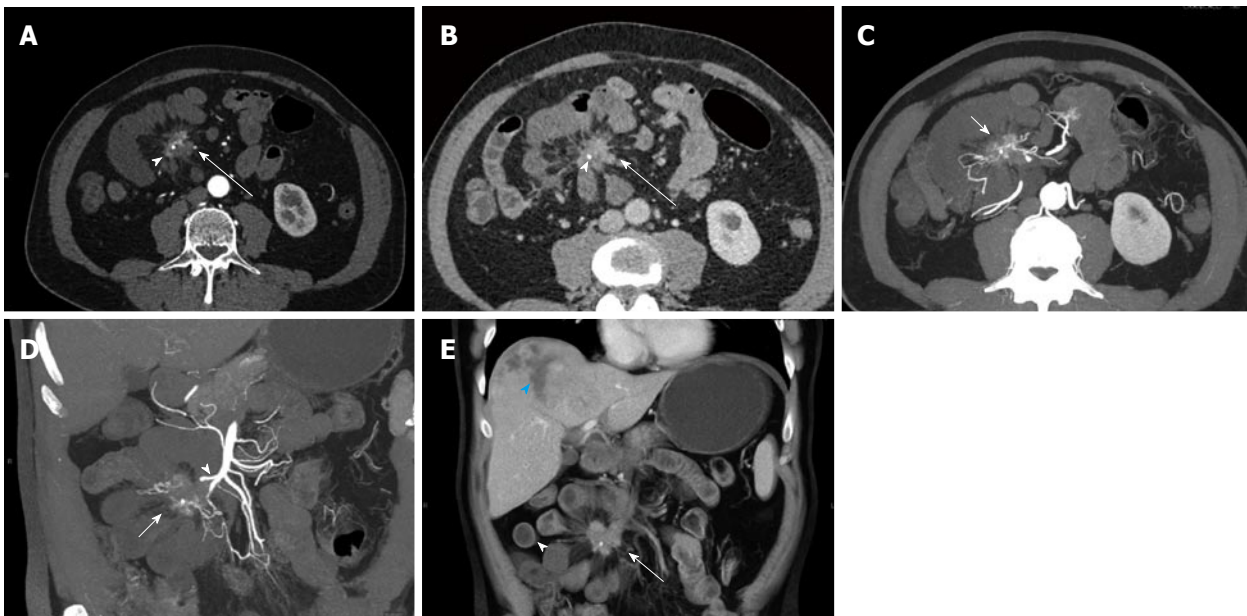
Small bowel carcinoid. A 74-year-old male with small bowel carcinoid (Stage IV), incidentally detected during computed tomography (CT) for presumed kidney stones. He subsequently described a history of flushing and diarrhea, and his urine 5-HIAA level was found elevated. In this case the primary tumor could not be detected on CT. Surgery and pathology demonstrated a polypoid 2 cm mass in the small bowel, likely not detected on CT due to bowel ischemia of the bowel segment involving the tumor. Local nodal metastatic and liver metastatic disease were present. A, B: Axial arterial phase (A) and venous phase (B) images show a hyperenhancing mesenteric mass surrounded by spiculations (arrows) with a small focal calcification (arrowheads), compatible with local nodal metastatic disease with desmoplastic reaction. Multiple dilated small bowel loops with hypoenhancing walls surround the mesenteric mass compatible with the surgical finding of bowel ischemia; C, D: Axial (C) and coronal (D) thick slab MPR images allow the depiction of the relationship of the mesenteric mass (arrows) to the SMA (arrowhead) and the adjacent bowel. The SMA appears irregular and is partially encased by the mass; E: Coronal VRT image allows good visualization of spatial relationships of mesenteric mass (arrow) with calcification, ischemic dilated small bowel loops (arrowhead) and a necrotic liver metastasis in the liver dome (blue arrowhead). VRT: Volume rendered technique; MPR: Multiplanar reconstructions; SMA: Superior mesenteric artery.
